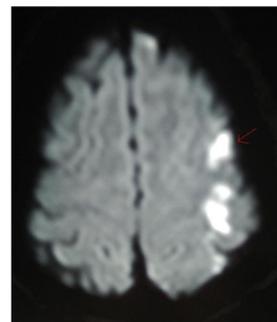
MRI brain diffusion weighted images showing hyperintensity suggestive of acute infarct in precentral and post central region suggestive of Left Middle cerebral artery Infarct.
